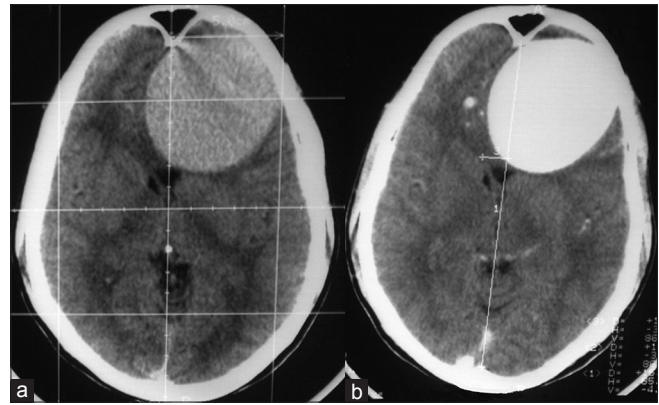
Computed tomography scan of brain showing a left frontal large well circumscribed round smooth walled strong and uniformly enhancing hyper dense space occupying lesion with peripheral wall calcification. The lesion demonstrates no obvious perilesional edema with significant mass effect with midline shift
